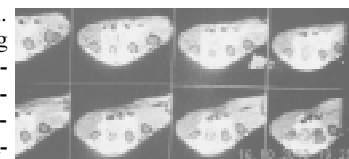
MRI hand showing Hyperintense to isointense soft tissue mass lesion
